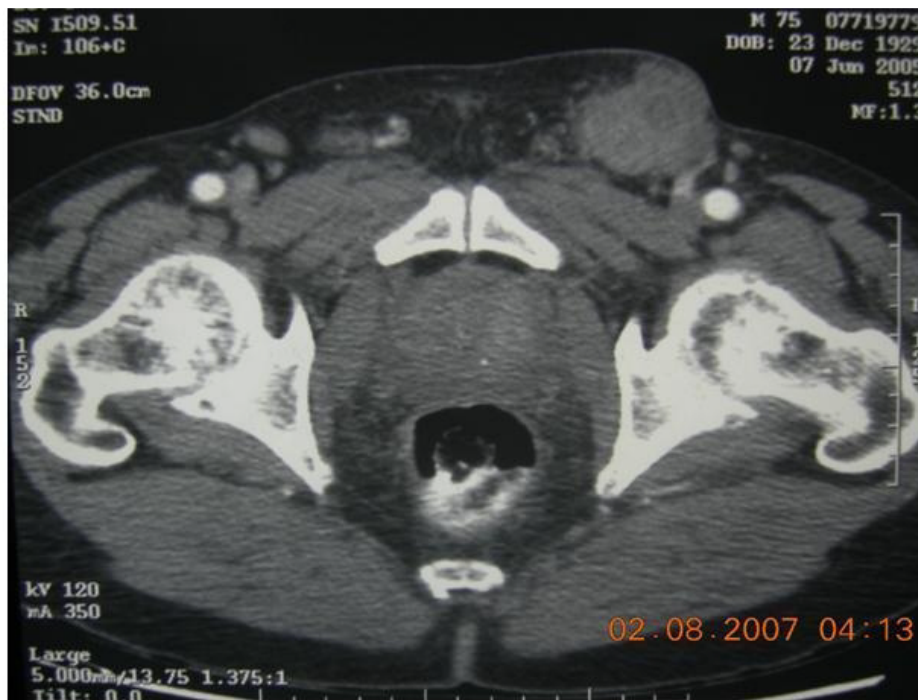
CT scan showing enlarged Bilateral Inguinal lymph nodes
